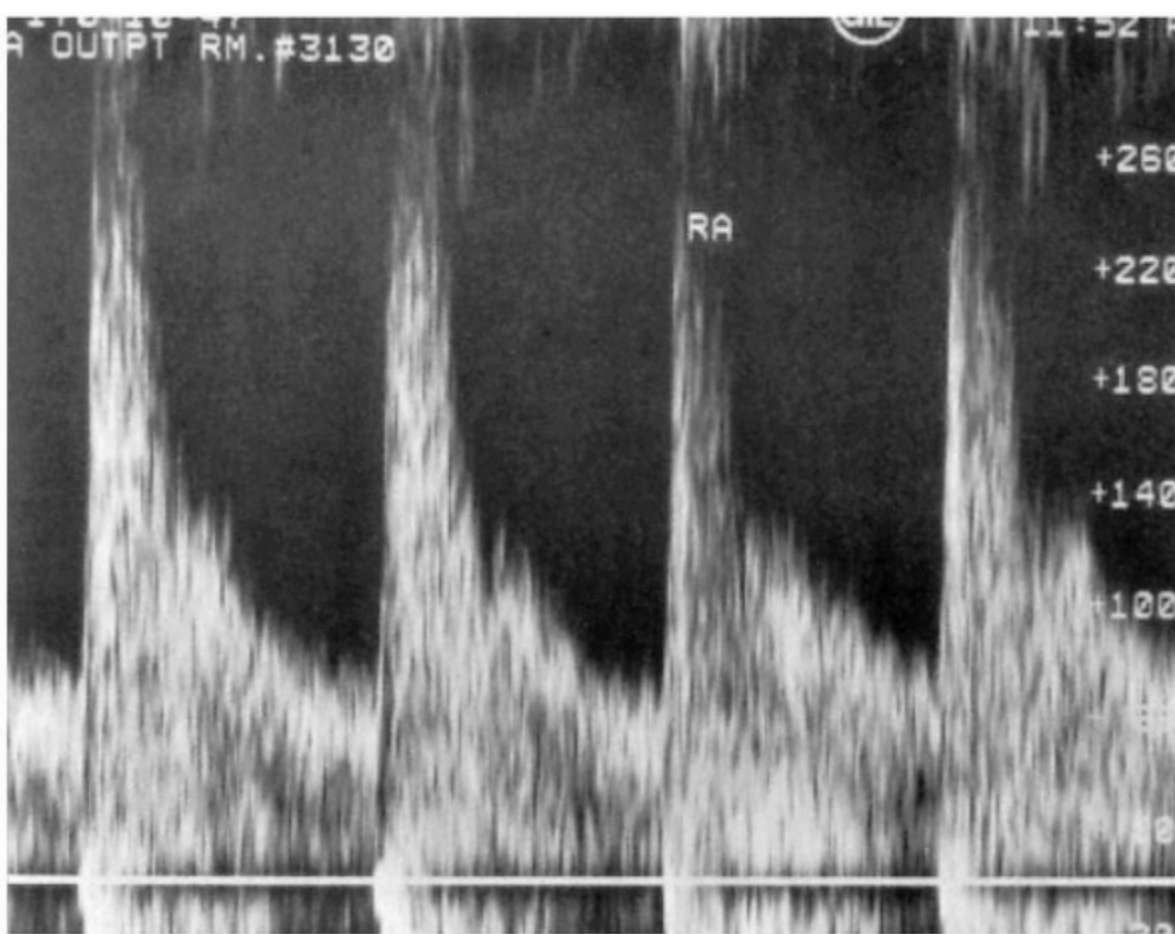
Renal artery stenosis. Doppler spectrum demonstrates focal elevated peak systolic velocity (faster than 260 cm per second), with mild spectral broadening at the anastomosis.
